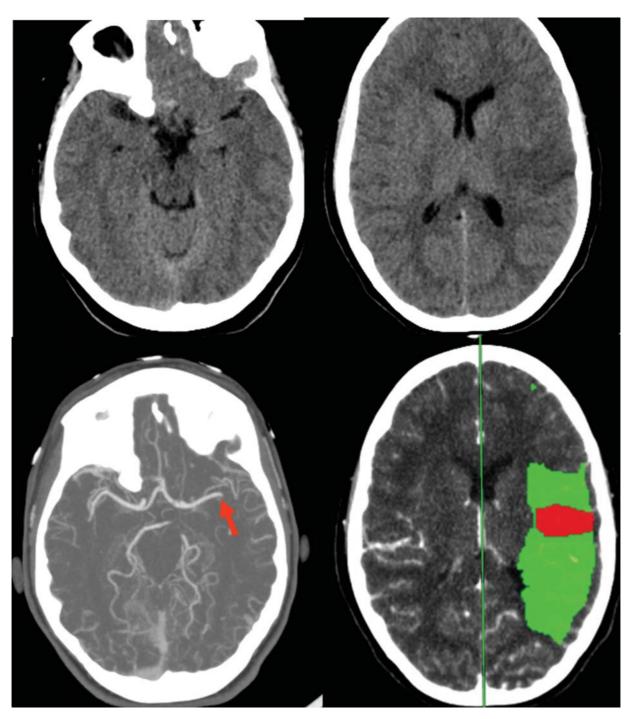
Brain CT scan performed 7 hours after onset. CT scan demonstrates an area of hyperacute ischemia in the temporoinsulofrontal area in the left MCA region and CT perfusion scan reveals an ischemic core surrounded by an extended area of ischemic penumbra. The arrow in Fig. 1 shows M1–M2 segment occlusion of MCA at CTA scan. The arrow in ►Fig. 2 shows M1–M2 segment occlusion of MCA at angiography. CT, computed tomography; CTA, CT angiography; MCA, middle cerebral artery.
